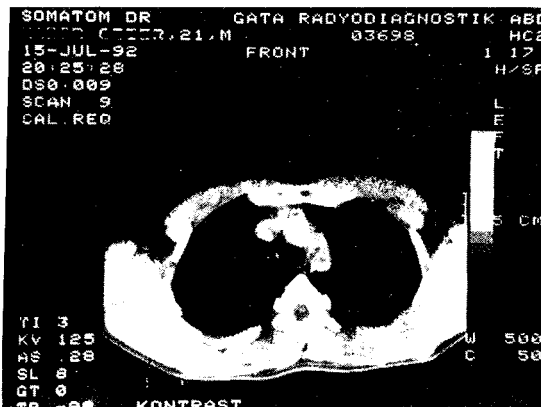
The thickened pleura on CT.
